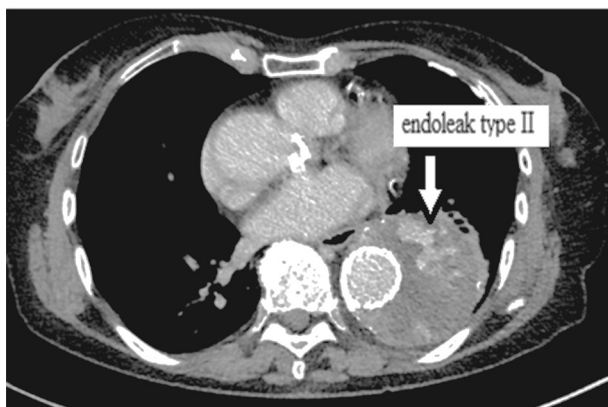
CTA of a patient with type II endoleak.
